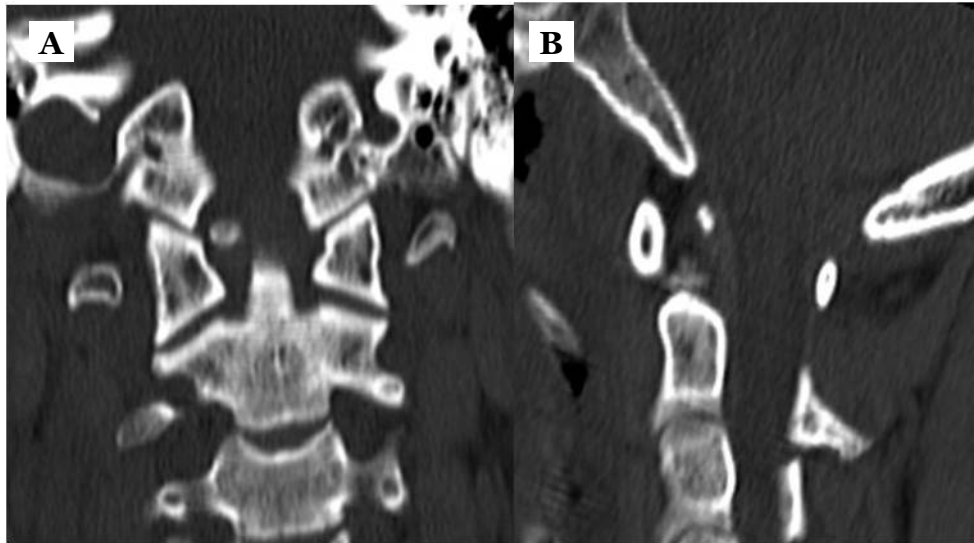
CT scan of the cervical spine (mid sagittal MPR) showing the basion-dens interval, which measures about 4.3 mm
